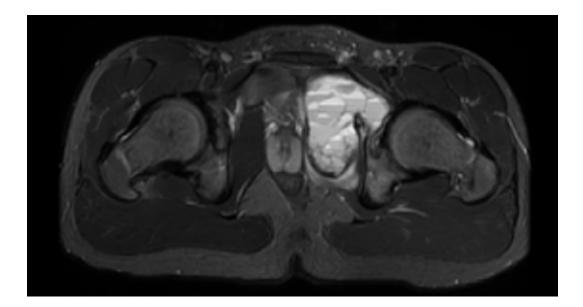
Numerous fluid-fluid levels appreciated on magnetic resonance imaging
